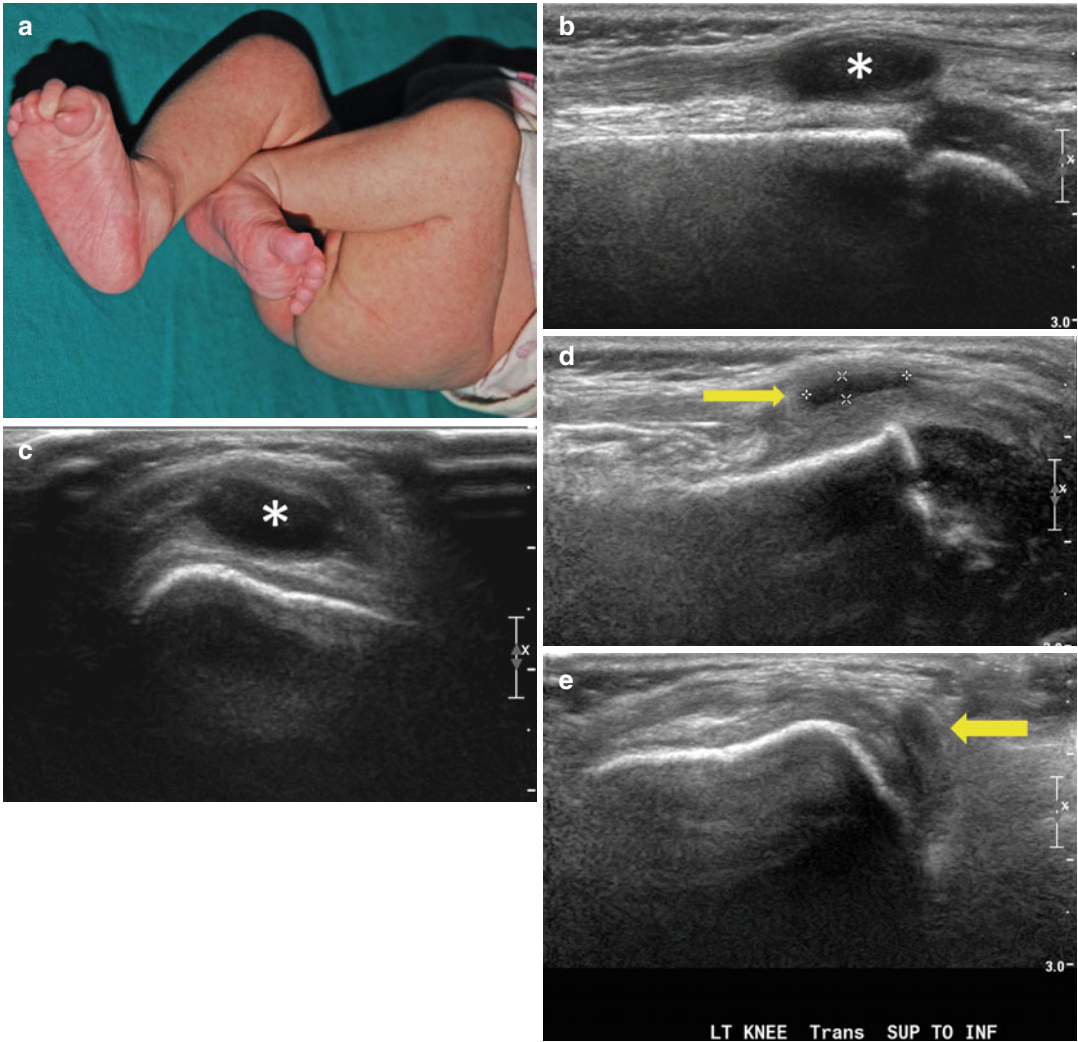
Congenital dislocation of the left patella (a); the flexion deformity of the knee and external rotation of the leg are seen. The sagittal (b) and transverse (c) ultrasound scans of the right knee demonstrate a normal size patella
